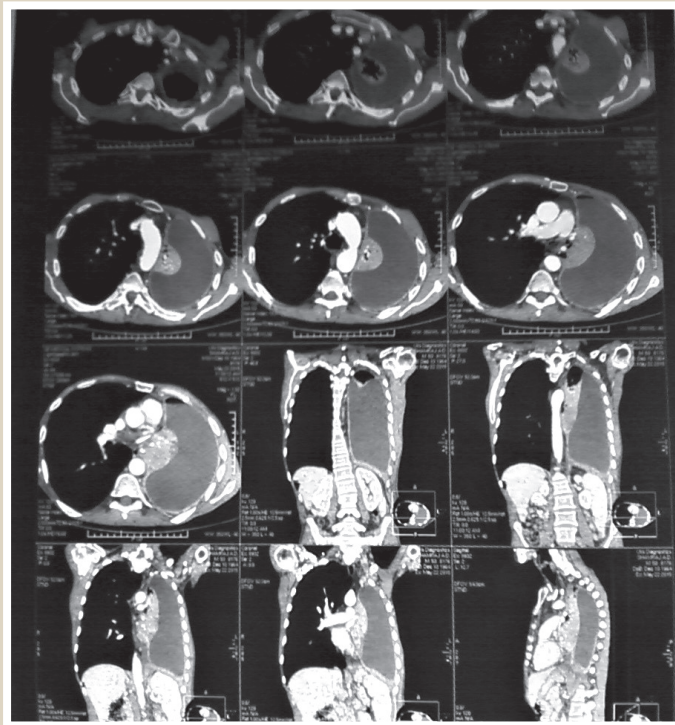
CT OTC after 7 months of the maintenance phase of pulmonary MRTB treatment.
